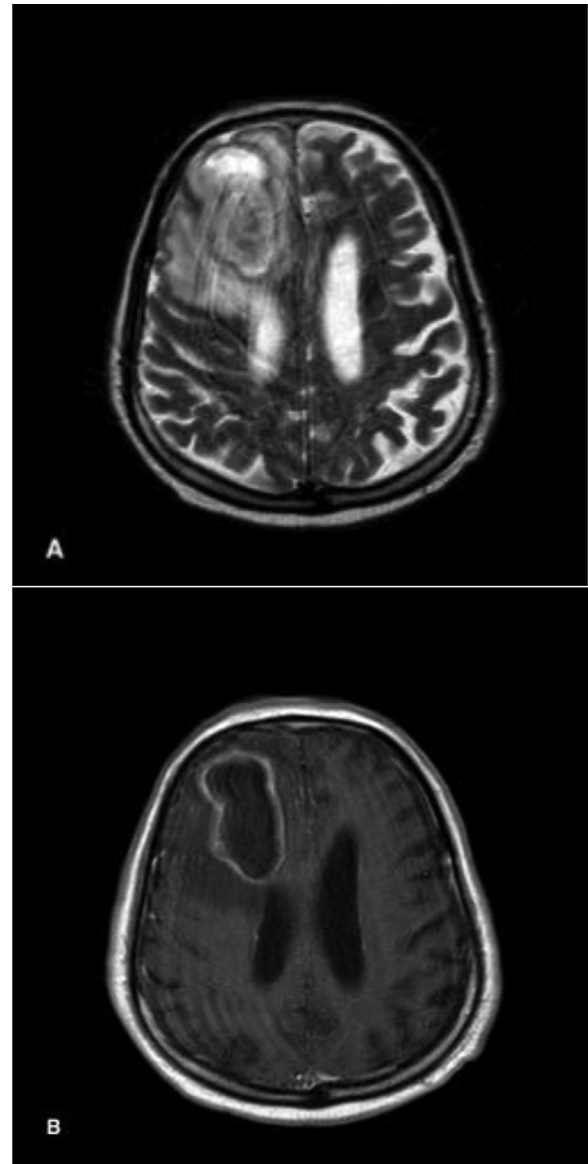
Conventional axial magnetic resonance images. (A) T2-weighted image shows a hyperintense abscess with a thin hypointense capsule and peripheral hyperintense edema. (B) T1-weighted image after gadolinium shows a ring-enhancement of peripheral capsule of abscess.
